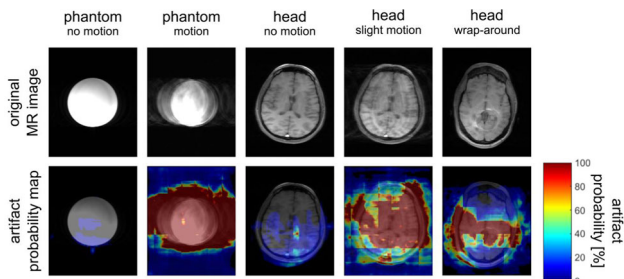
Exemplary MR images with artifact probability maps (probability in %). Distinct differences are visible between motion-free and motion-corrupted images. Moreover, a wrap-around artifact is visible on the MR image farthest to the right.
